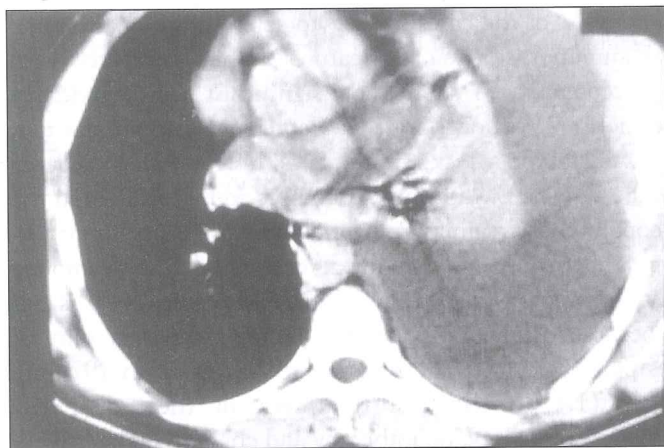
Chest CT of the patient: Massive pleural effusion with atelectasia in the left lung and a mass 50 mm in diameter mass on the lateral wall of the left hemithorax, with destruction of adjacent ribs.
